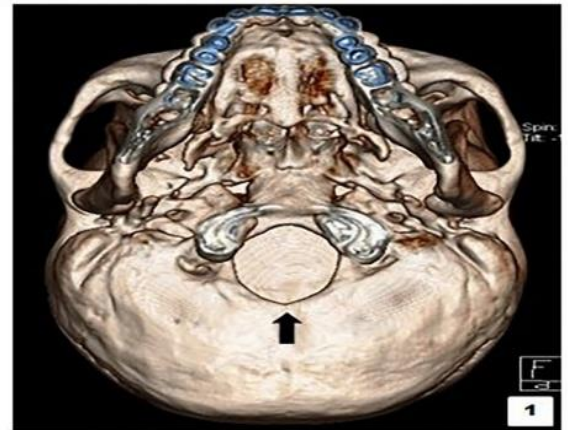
3D reconstructed computed tomography scan - axial view shows foramen magnum (black arrow).
